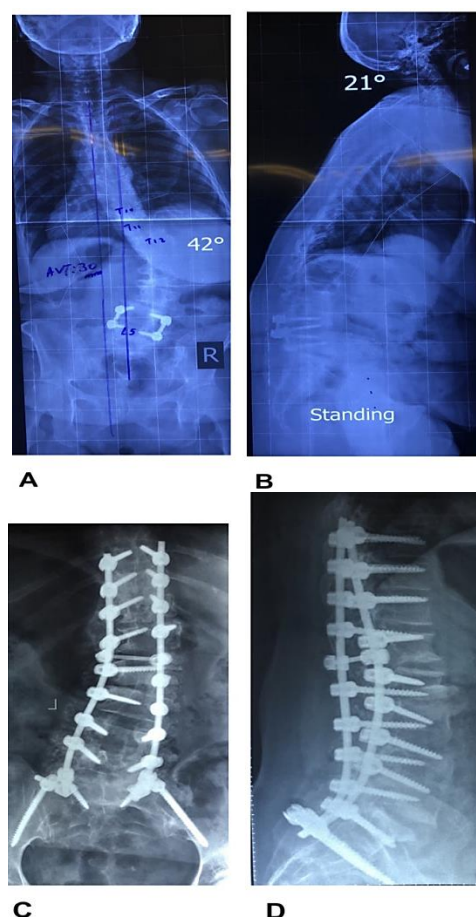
Preoperative anteroposterior (AP) and lateral views (A, B) and corresponding postoperative standing radiographs (C, D) of a 58-year-old woman with iatrogenic lumbar kyphosis, proximal junctional kyphosis (PJK) deformity, and sagittal imbalance treated with V-shaped osteotomy.
